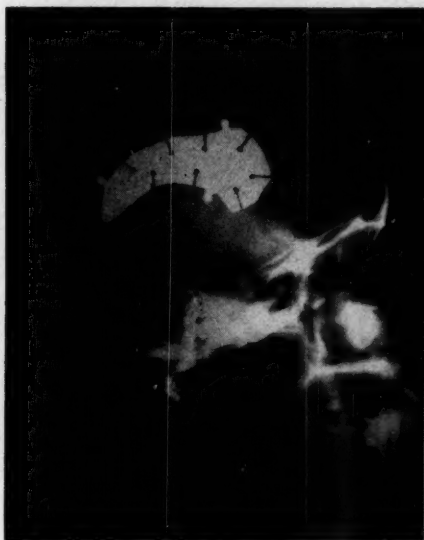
Postoperative roentgenograms.
